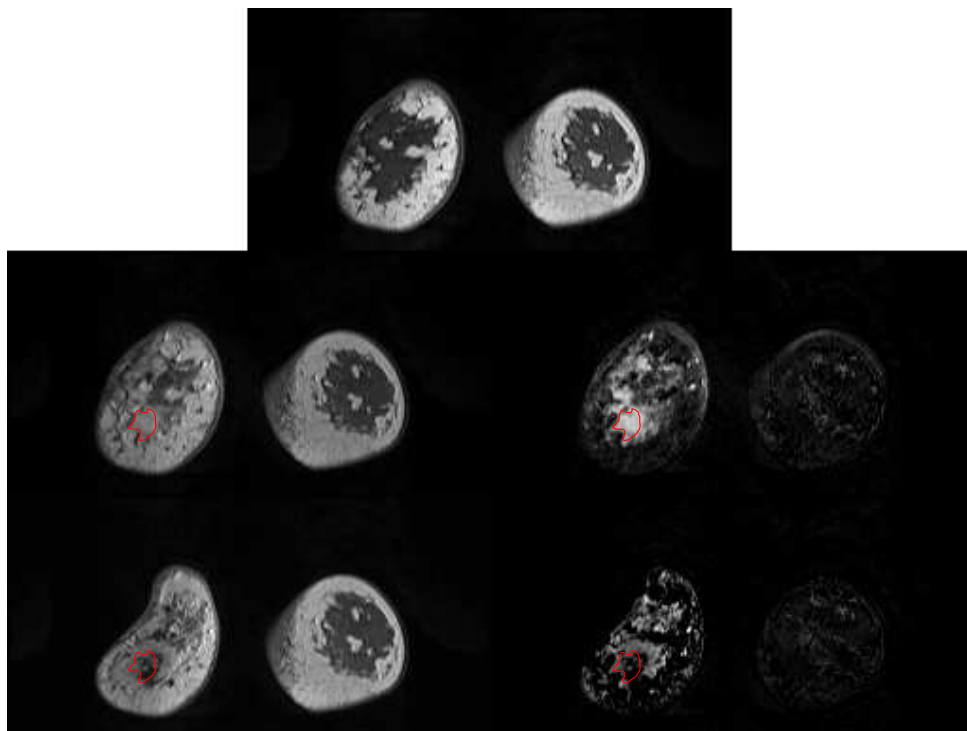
A representative case in which some evident artefacts are introduced by an improper MCT (3D free-form deformation with cubic interpolation). It is clear that the new artefacts could lead to an unreliable lesion evaluation. In the first row is shown the pre-contrast MRI data. In the middle row is presented: on the left, an MRI image from the post-contrast series (about 3 min. after the injection) without motion correction and on the right, the corresponding *subtractive* image. The *subtractive* image emphasises regions in which the contrast agent has mostly flowed. In the last row (after motion correction), the post-contrast image (left) and the corresponding *subtractive* image (right) are presented. An inappropriate MCT not only can introduce evident artefacts but also can impinge on the contrast agent effect undermining the final results. Specifically, can be observed a decrease of the enhancement in the manually segmented region of interest (in red).
